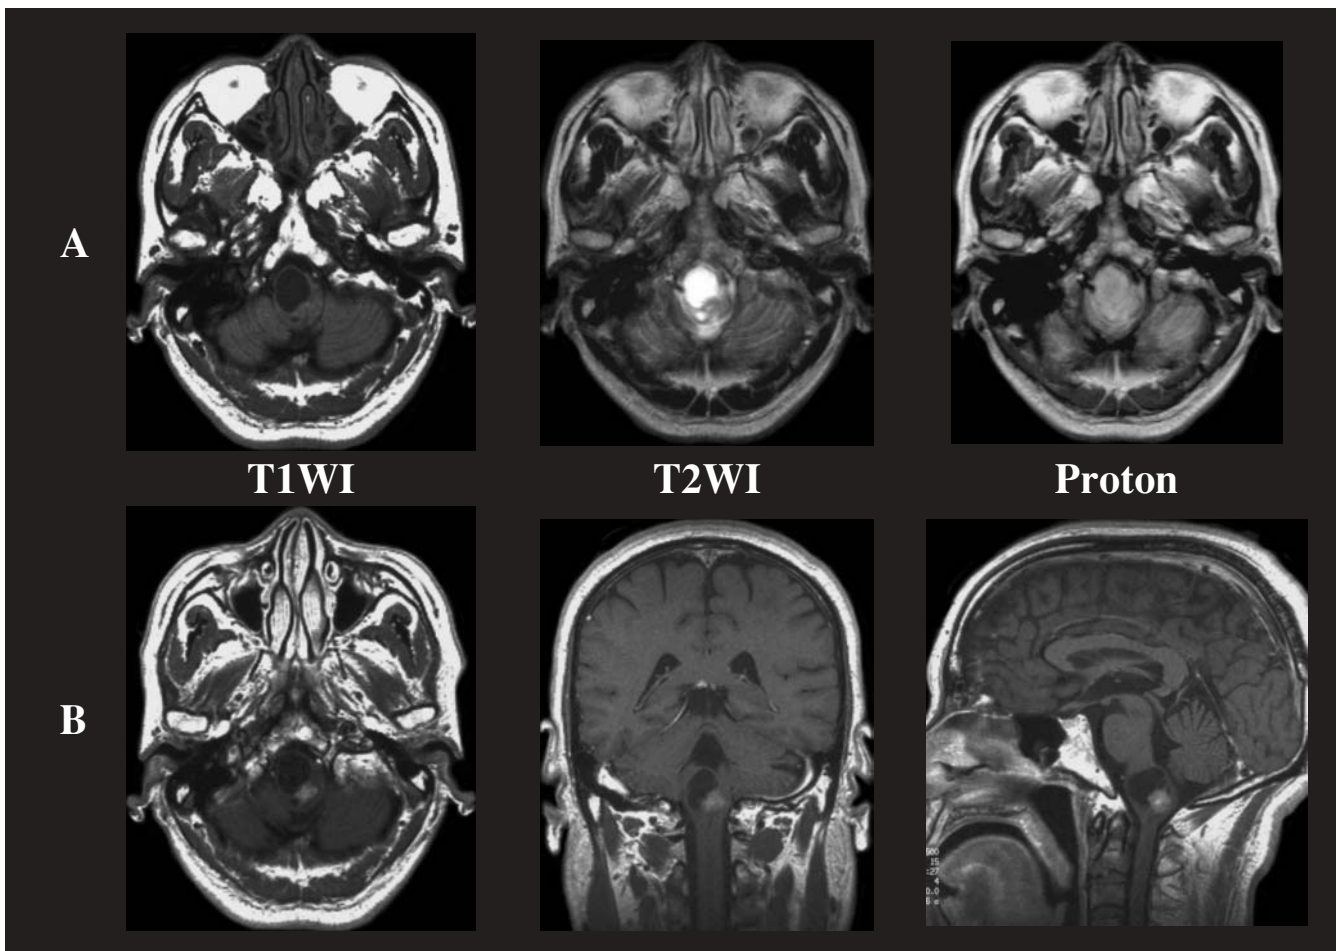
Pre-first operative MRI (A Plane, B Gd-GTPA enhancement), showing a cystic tumor with a mural nodule in the cervicomedullary junction
